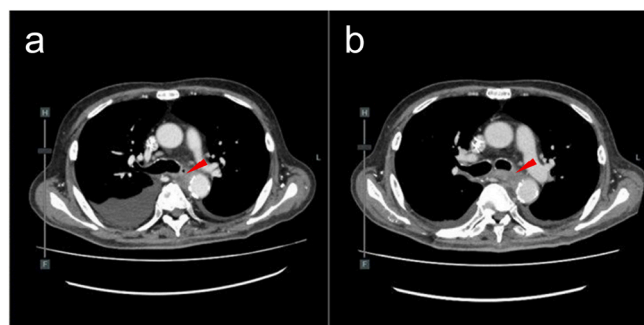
The solid lesion (the arrow head) of the middle mediastinum revealed by the CT. a. Computed tomography 2 months prior to admission. b. Computed tomography at this present admission. In Fig. 1b, there is a solid lesion near the esophagus and the thoracic aorta of the middle mediastinum. In Figs. 1a and 1b, there are slight lesions at the same site.
